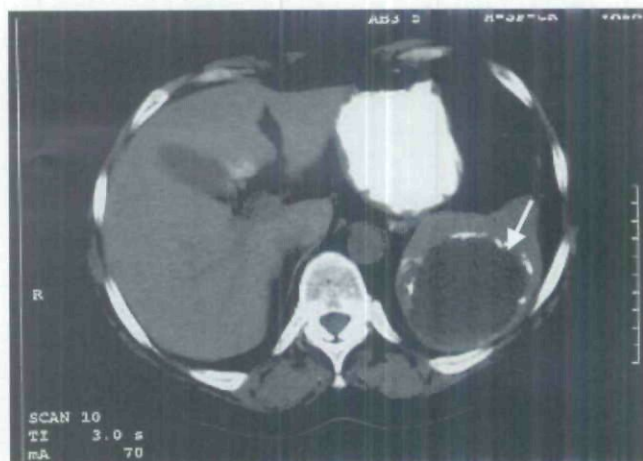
Splenic pseudocyst. Several months after blunt abdominal trauma, this patient presented with left upper quadrant pain. A computed tomography scan of the abdomen demonstrating a large, well-defined cystic lesion of the spleen with a calcified rim (arrow). These imaging features are typical for a splenic pseudocyst.
